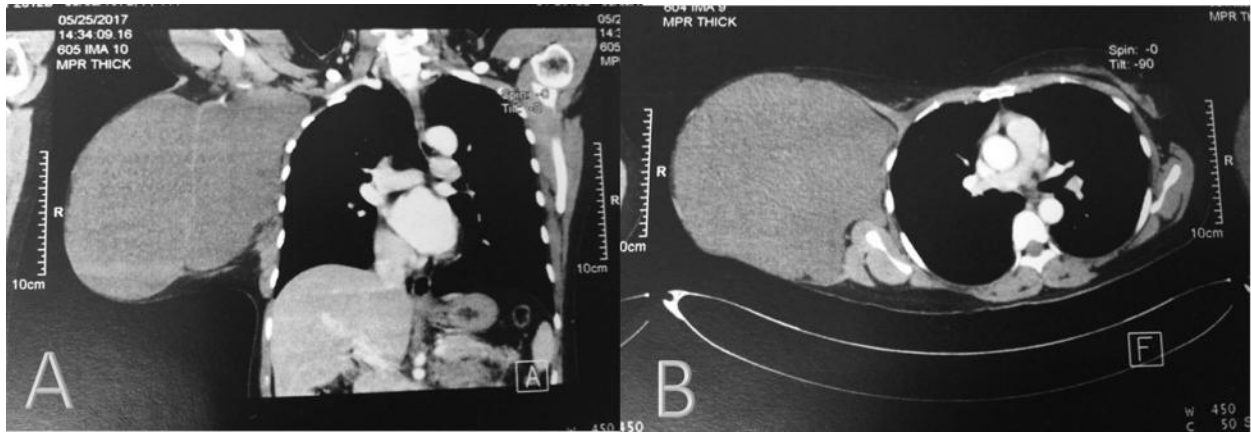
CT scan of the chest. A, Coronal view. B, Axial view.
